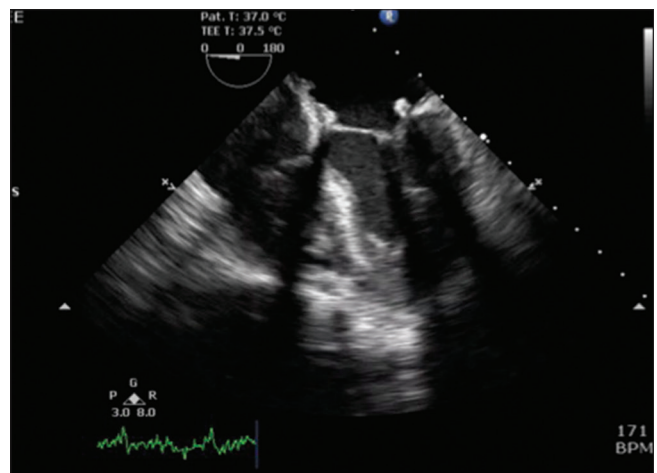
Intraoperative transesophageal echocardiography shows a disappearance of hyperechoic structure after left atrium filling
